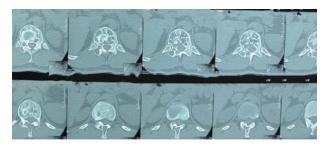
Case 1, Axial CT scan of twelfth thoracic spine vertebrae.
